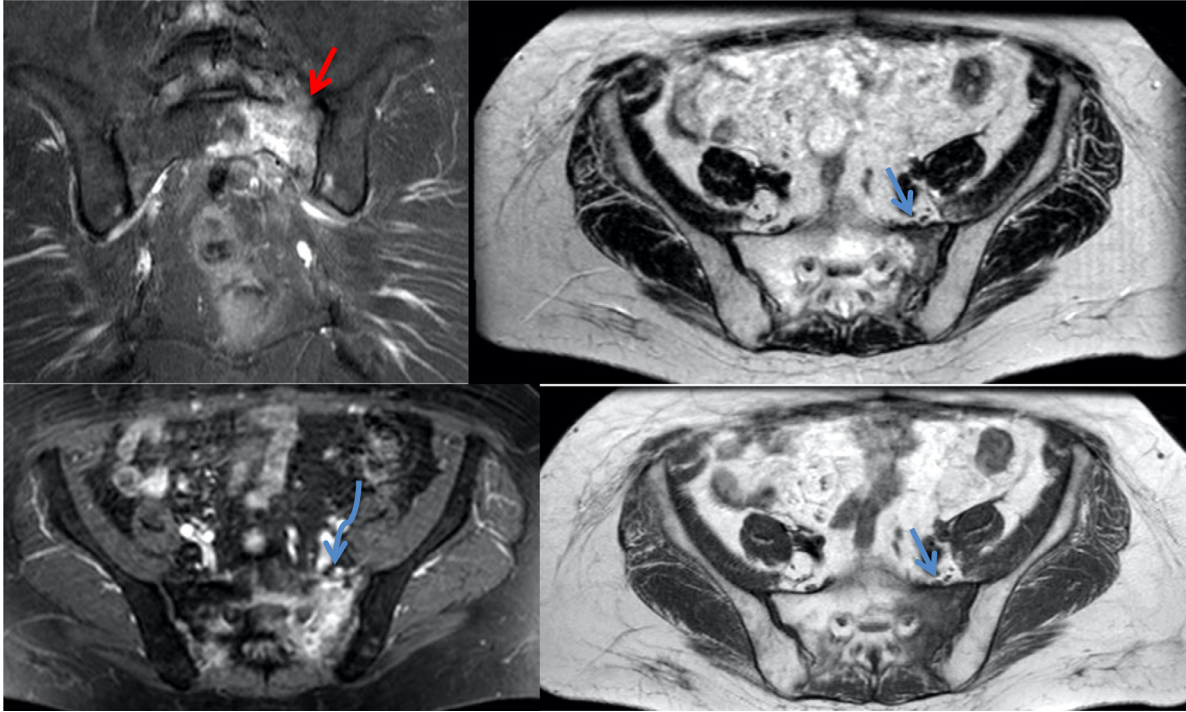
Case 1. Altered MRI signal zones in sacrum (more on the left side) in T1 and T2 sequences (straight blue arrows) with contrast material accumulation (curved blue arrow) and hyperintense signal zones in STIR sequence (red arrow). (Color version of figure is available online.)
